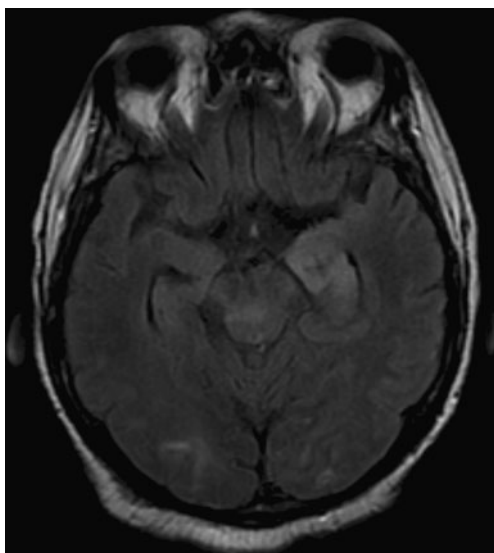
MRI brain revealed multifocal T2 hyperintensities most prominent in the left mesial temporal lobe
